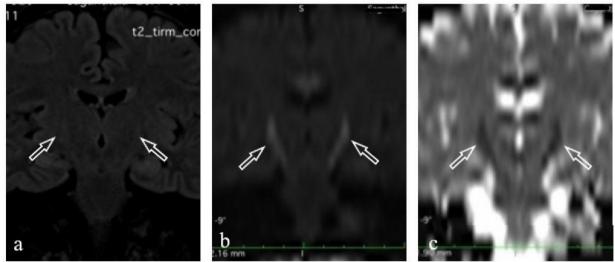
MRI of another patient showing coronal image of FLAIR (a), coronal reformatted images of DWI (b) and corresponding ADC mapping (c) reveals bilateral symmetrical hyperintensity with diffusion restriction (open arrows) in the corticospinal tract.
